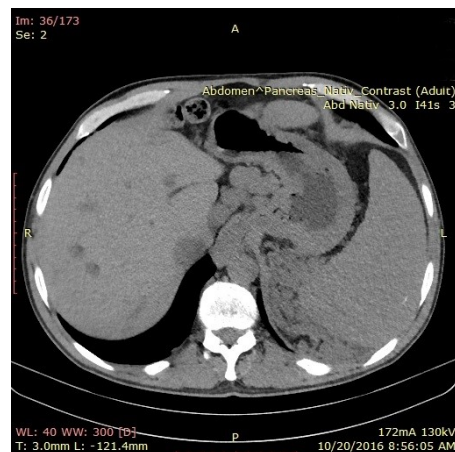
Possible liver metastasis revealed by CT scan
